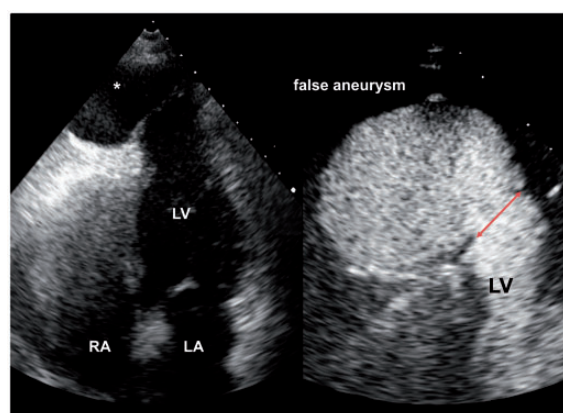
Four-chamber view with incidental finding of a confined echo-free area asterisk denotes adjacent to the LV apex (left). Contrast echocardiography confirms a large false aneurysm, four-chamber view, zoomed apex, and the red arrow shows the neck of the aneurysm.⁷⁵
